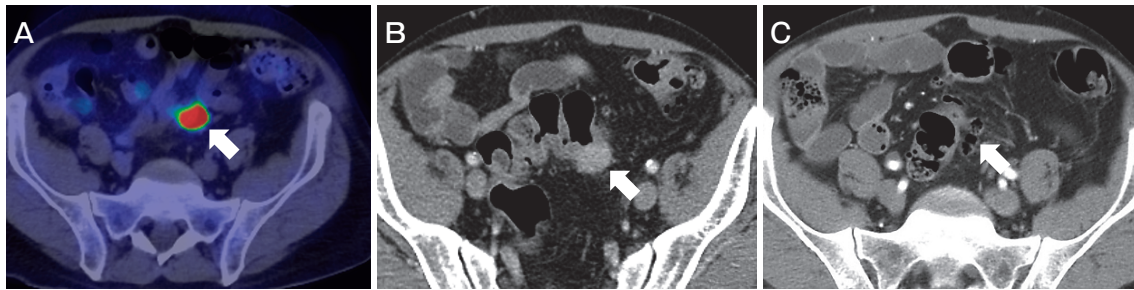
PET and CT images. Tracer uptake is noted in the colon (A, arrow). A tumor showing enhancement in the presence of contrast media was observed (B, arrow). The tumor was not detected 15 months earlier, but diverticula were observed (C, arrow).
